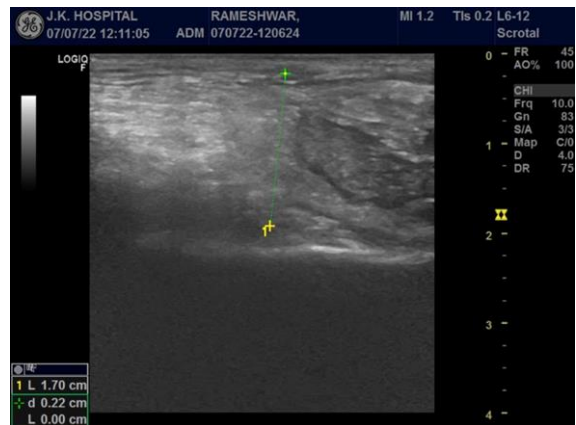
Ultrasound image showing defect seen in anterior abdominal wall of inguinal region
